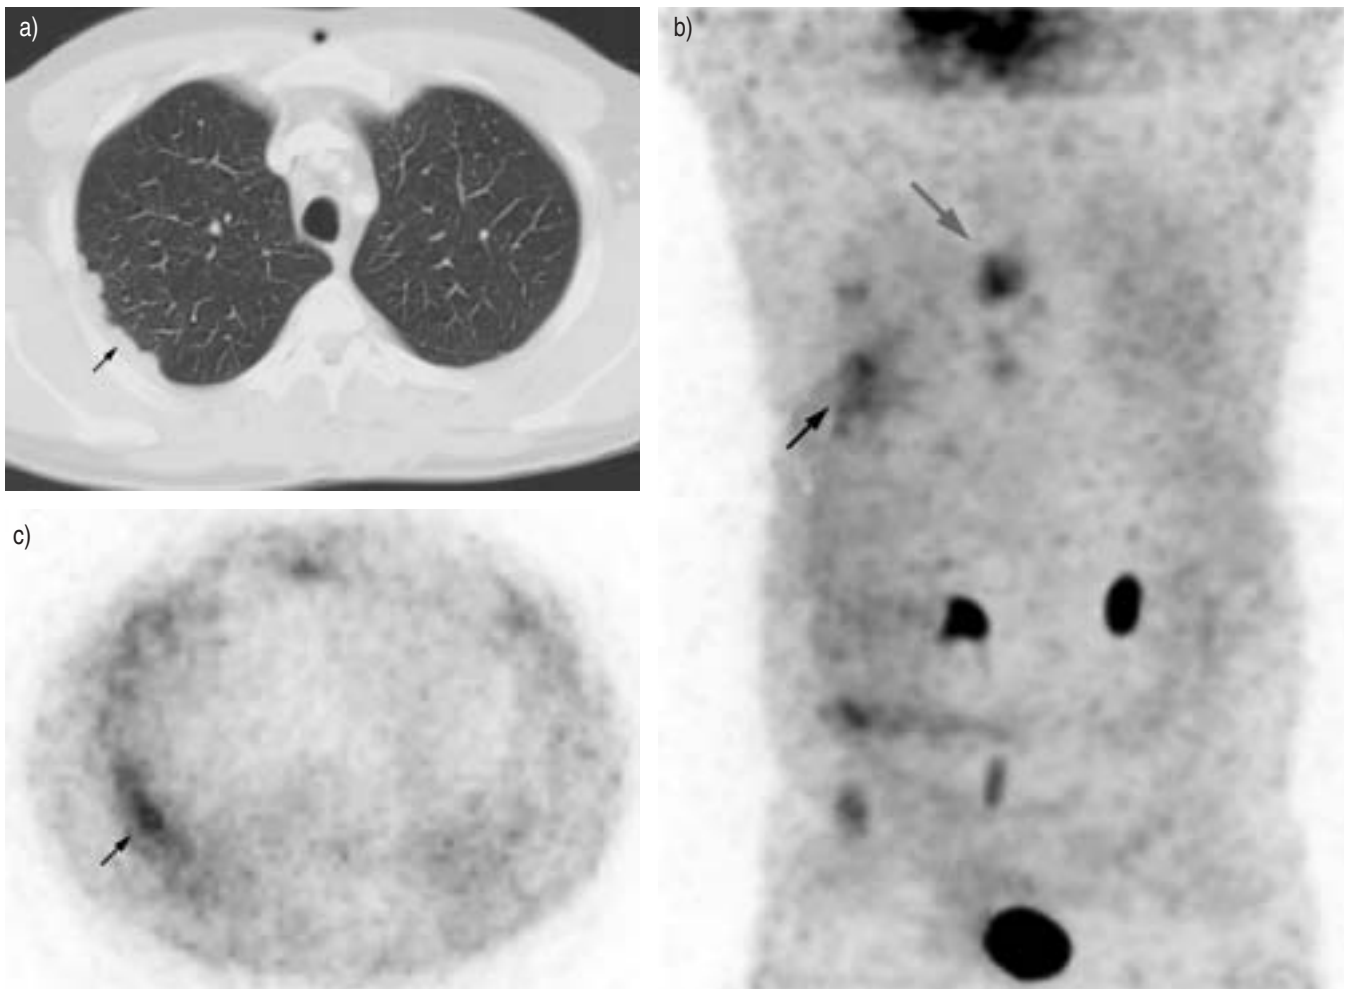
A 43-yr-old patient with epithelial mesothelioma. a) Computed tomography scan revealed right-sided nodular pleural thickening (arrow). b) Three-dimensional imaging in maximum pixel raytrace in the anterior view revealed pleural involvement (arrow) and increased focus of ¹⁸FDG uptake by mediastinal lymph node (grey arrow). c) Transverse ¹⁸F-fluorodeoxyglucose (¹⁸FDG) imaging *via* coincidence detection emission tomography images demonstrated localised pleural hypermetabolism (arrow).
